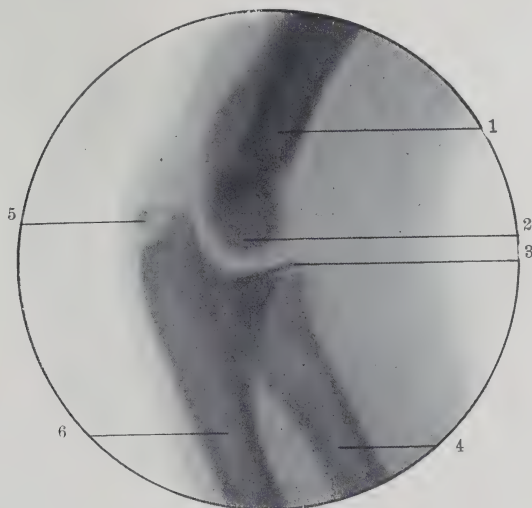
Radiograph Showing Lateral View of Elbow at Ten Years. 1, Humerus; 2, capitellum; 3, upper epiphysis of radius; 4, radius; 5, epiphysis of olecranon; 6, ulna. (Original.)
